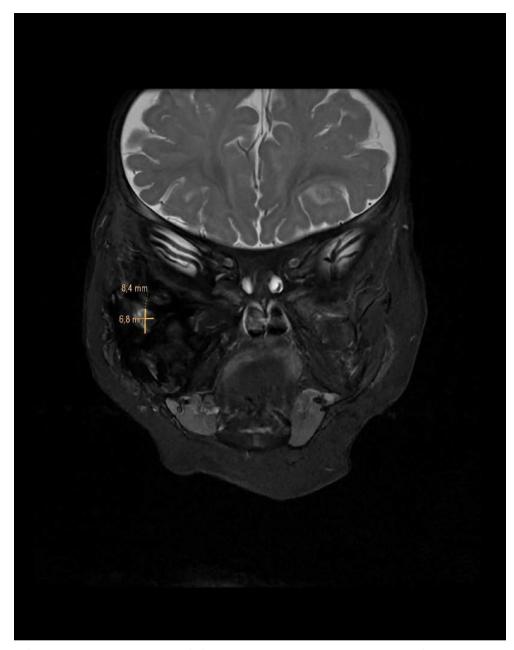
MRI of the head and neck on Month 10 of life, showing a small contrast enhancing lesion of  $1 \times 0.7 \times 1.1$  cm close the right collum mandibulae.
